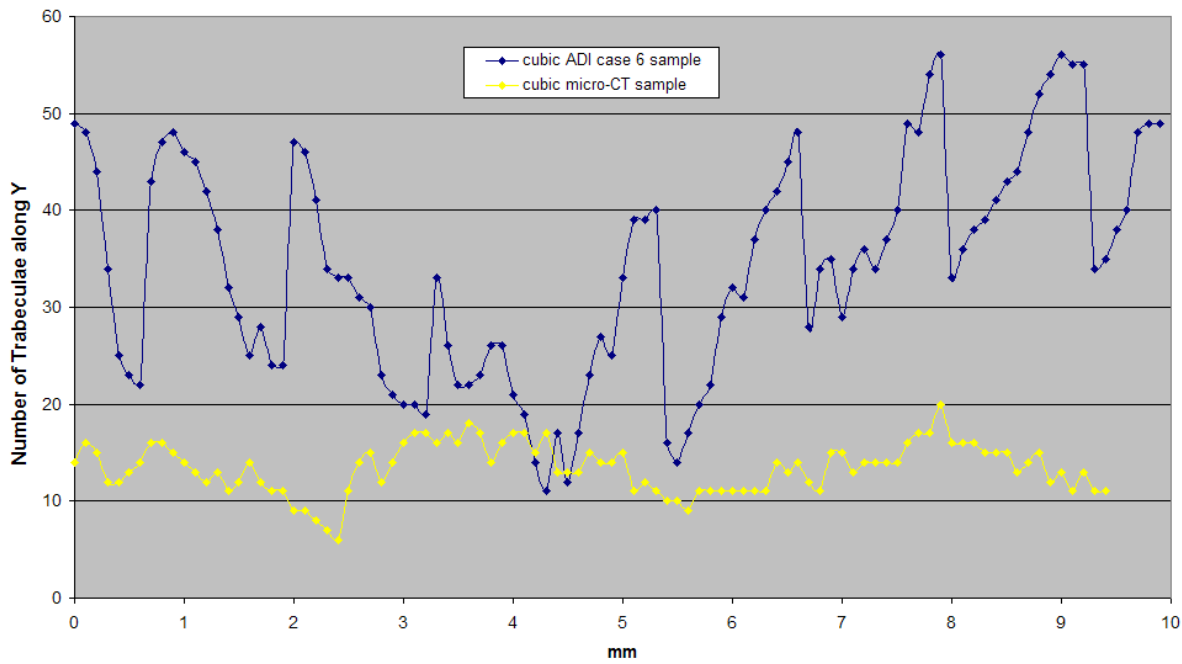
Comparison of trabecular area along *Y* between the cubic ADI case 6 sample and cubic  $\mu$ CT sample
